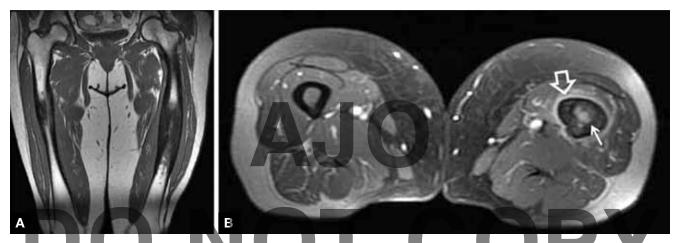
The T1-weighted coronal (A), and axial (B) fat suppressed contrast enhanced T1-weighted MRI show the sclerosis with low signal intensity on both pulse sequences. Adjacent soft tissues (open arrow) and medullary cavity (thin arrow) demonstrate mild enhancement after gadolinium administration.
